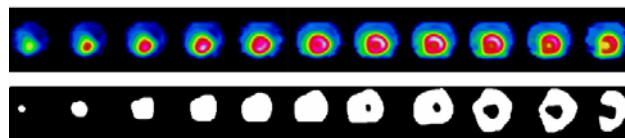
Delineation of the epicardium and the endocardium in 2D scintigraphic data sequence.
